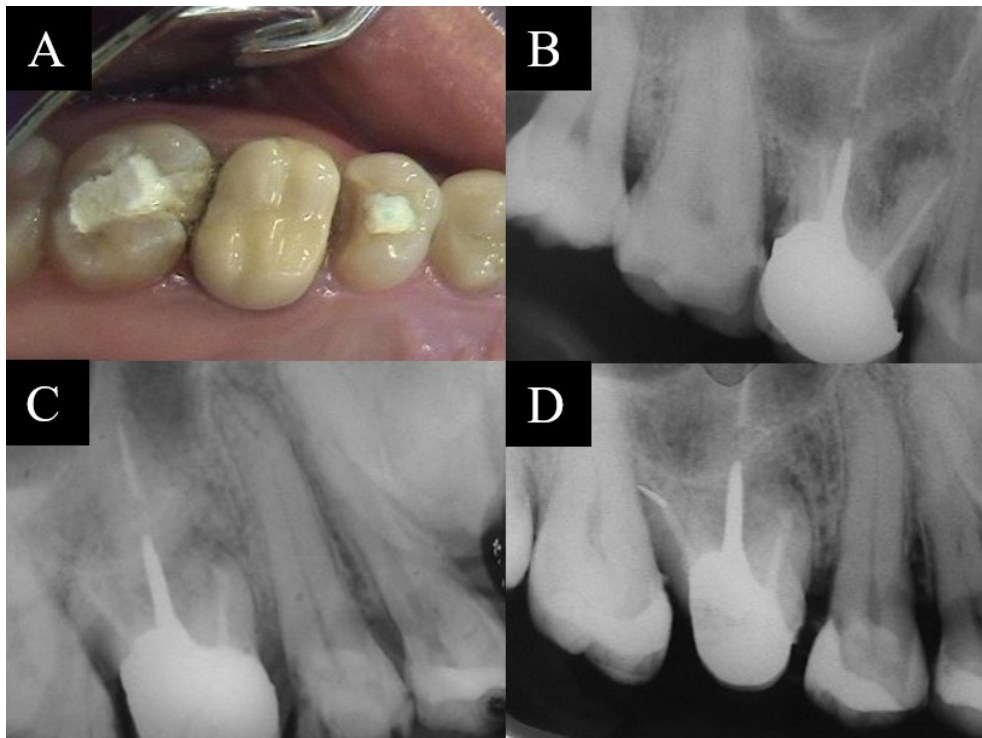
A. Occlusal view of the 16th. B. Radiograph May 2004. C. Radiograph December 2004. D. Radiograph May 2005.
